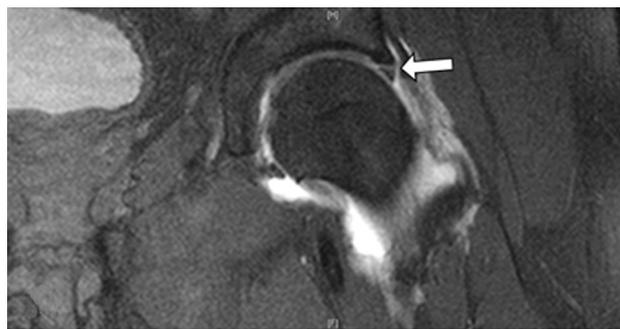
Initial MRI coronal T1 image showing labral tear (*arrow*) and oedema
